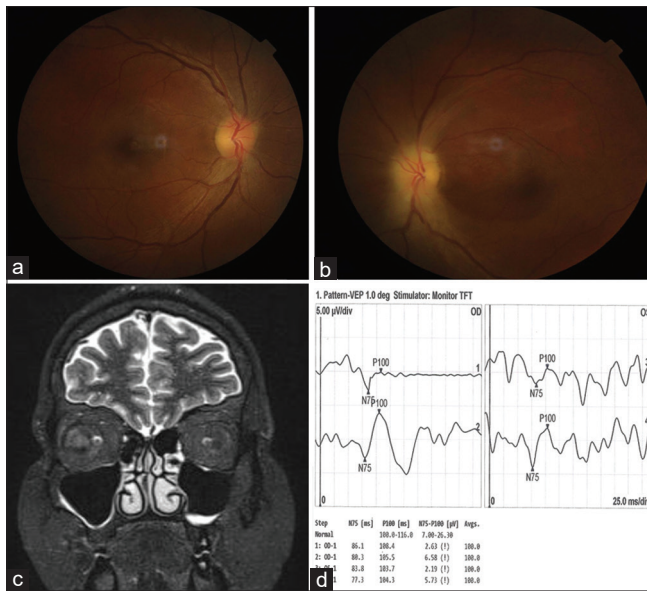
Fundus images of both eyes at presentation showing normal disc and macula (a and b), magnetic resonance imaging of the orbits at presentation (c) showing hyperintense lesion in the left optic nerve (red arrow), and pattern visual evoked potential at 1 week (d) showing increased latency and decreased amplitudes in the left eye
